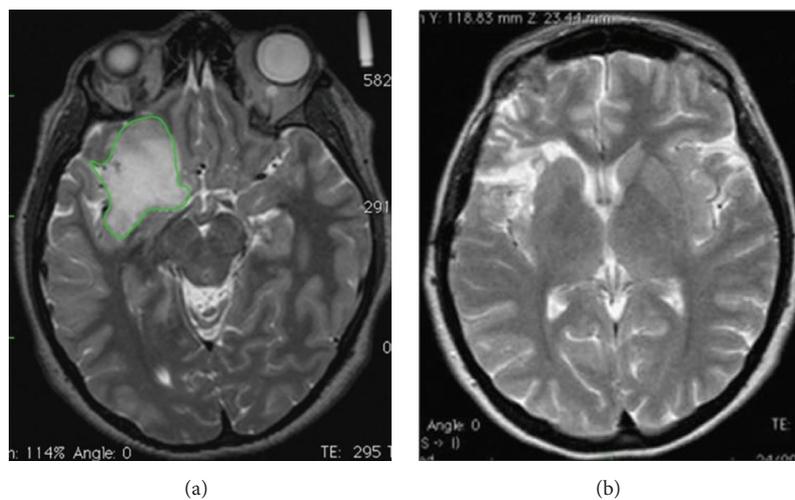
A case of right insular oligoastrocytoma. (a) The preoperative tumor volume computed on postcontrast T2-weighted MRI was 53 cm<sup>3</sup> (axial slices). The green line represents the area of the tumor before the first surgery. Tumor volume was computed with OSIRIX software. (b) Postoperative tumor residue computed on T2-weighted MRI showed a tumor residual volume of 3 cm<sup>3</sup> (axial slices). The extent of the tumor volume resection, computed on a T2-weighted MRI sequences, was 94%.
